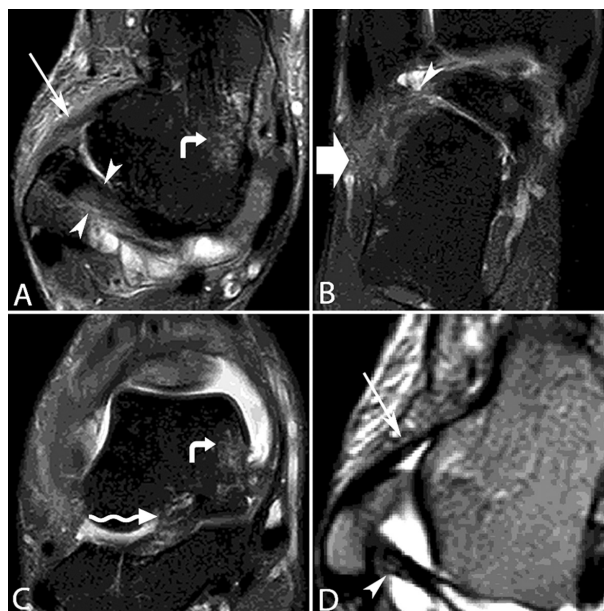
MRI DP-SPAIR images (A, B, C) of a young male obtained after traumatic inversion ankle sprain; image A (axial view) shows the lesion of the ATF (arrow) and of the PTF (arrowheads); Image B (coronal view) shows the lesion of FC (thick arrow) and of the PTF (arrowhead); image C (coronal view) shows the lesion of the CL (corrugated arrow). Image A and C shows the spongiuous oedema of the medial area of the talus (curved arrow) caused by the impaction with the tibial malleolus. TSE T2w-axial view image (D) shows normal anatomy of ATF (arrow) and PTF (arrow head), highlighted by the presence of a intraarticular hyperintense effusion
